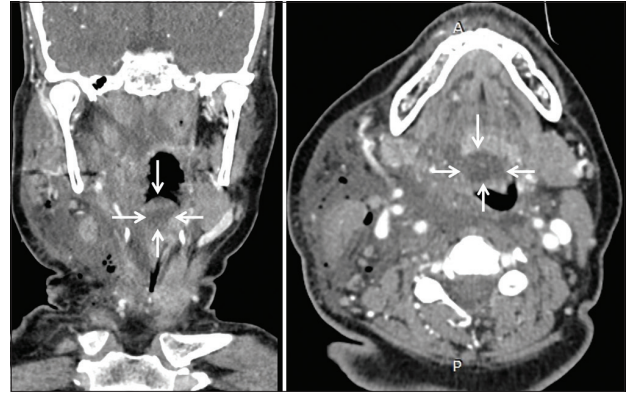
Coronal multiplanar reformat (left image) and axial (right image) postcontrast computed tomography images of the neck at the level of the epiglottis. There is a cystic lesion (1.8 × 1.6 × 1 cm) centered at the tip of the epiglottis, consistent with an epiglottic cyst (arrows). The right vallecula is completely obliterated, while the left vallecula is less affected. Furthermore, there is extensive edema of the soft tissues of the right lateral neck.
